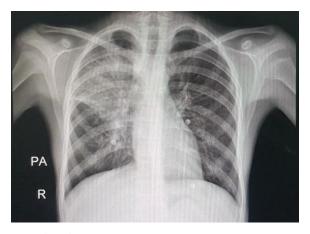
Post TB treatment chest X-ray
